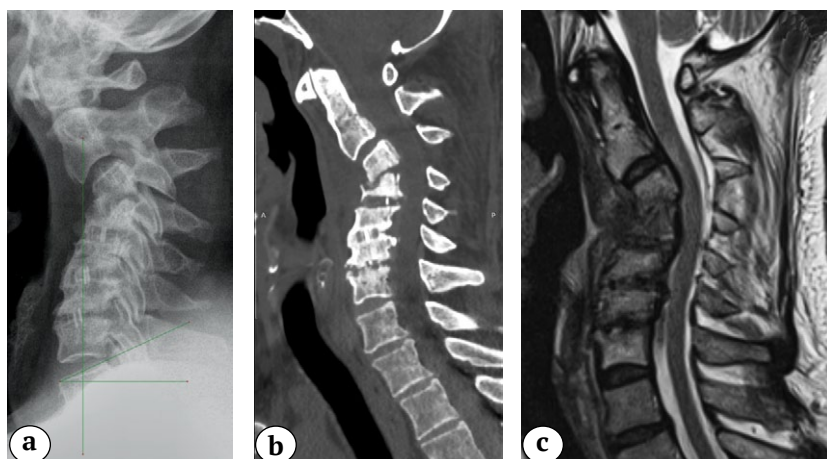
X-ray (a), CT (b) and MRI (c) at the time of hospital admission: angular kyphosis 48° Cobb, destruction of C3–C5, myelopathy at C2–C3, no signs of active inflammatory process (abscesses)
